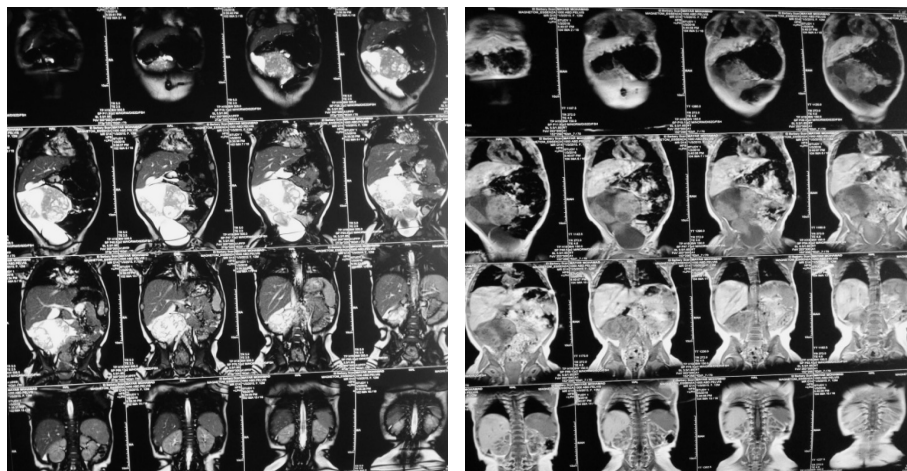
MRI (T1 & T2 weighted images), coronal views showing a large right adnexal cyst of one of our ovarian YSTs cases.
